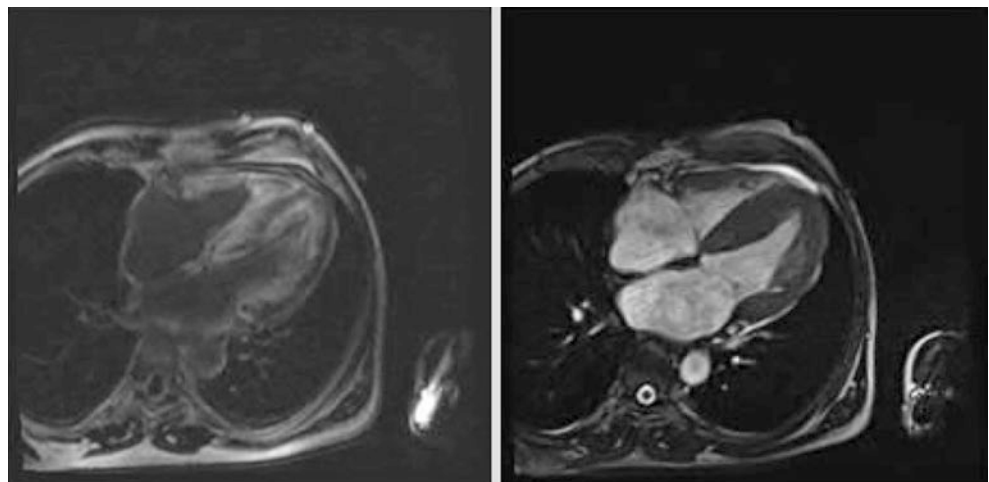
MRI of heart showing amyloid
